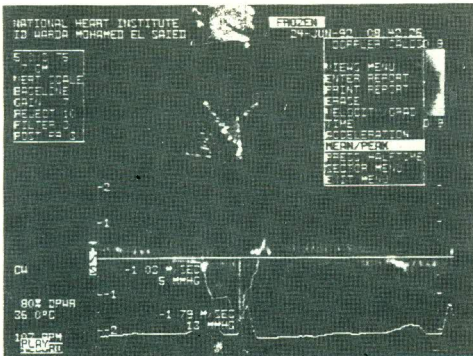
Pre-commissurotomy Doppler study showing mean and maximum transmittal gradient
